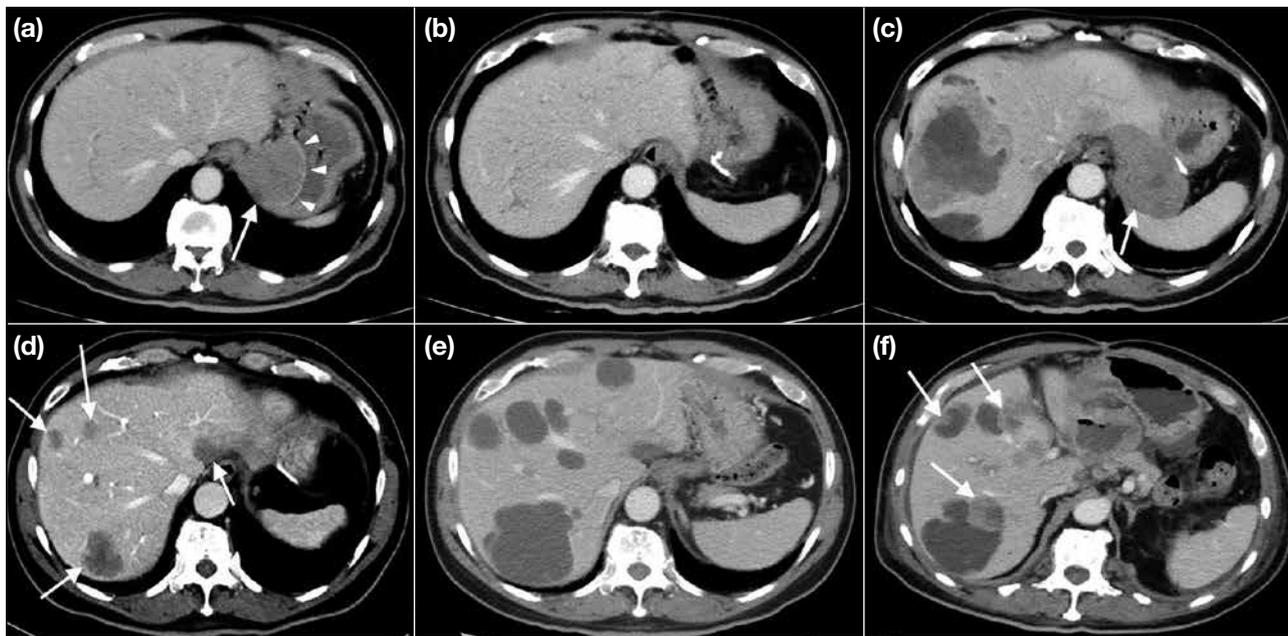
Metastatic gastric gastrointestinal stromal tumour in a 67-year-old man with liver metastases. Partial gastrectomy was performed and the patient was treated with imatinib. (a) Preoperative computed tomography (CT) scan showing a well-defined submucosal gastric mass (arrow) with smooth overlying intact mucosa (arrowheads). (b) Postoperative CT scan showing curvilinear hyperdense suture material at the stomach wall, compatible with partial gastrectomy. Fat strands in the surgical bed suggest postoperative changes. (c) Follow-up CT scan 4 years later showing a new heterogeneously enhancing mass in the surgical bed (arrow), suggestive of local recurrence. (d) Preoperative CT scan showing multiple hypodense solid liver masses (arrows), suggestive of liver metastases. (e) Follow-up CT scan 2 years after surgery showing multiple predominantly cystic lesions in the liver, in keeping with partial treatment response. (f) Follow-up CT scan 4 years after surgery showing new intratumoural solid lesions (arrows) within the previous cystic liver metastases, suggestive of disease progression.
